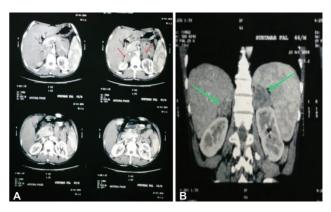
(A, B) CT scan of the abdomen showed bilateral adrenal enlargement.
